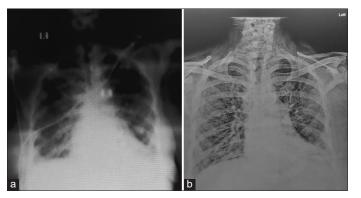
(a) Anteroposterior view of the chest radiograph on admission showing bilateral patchy areas of consolidation; (b) posteroanterior view of the chest radiograph after 2 months of hospital discharge showing ground-glass opacities
